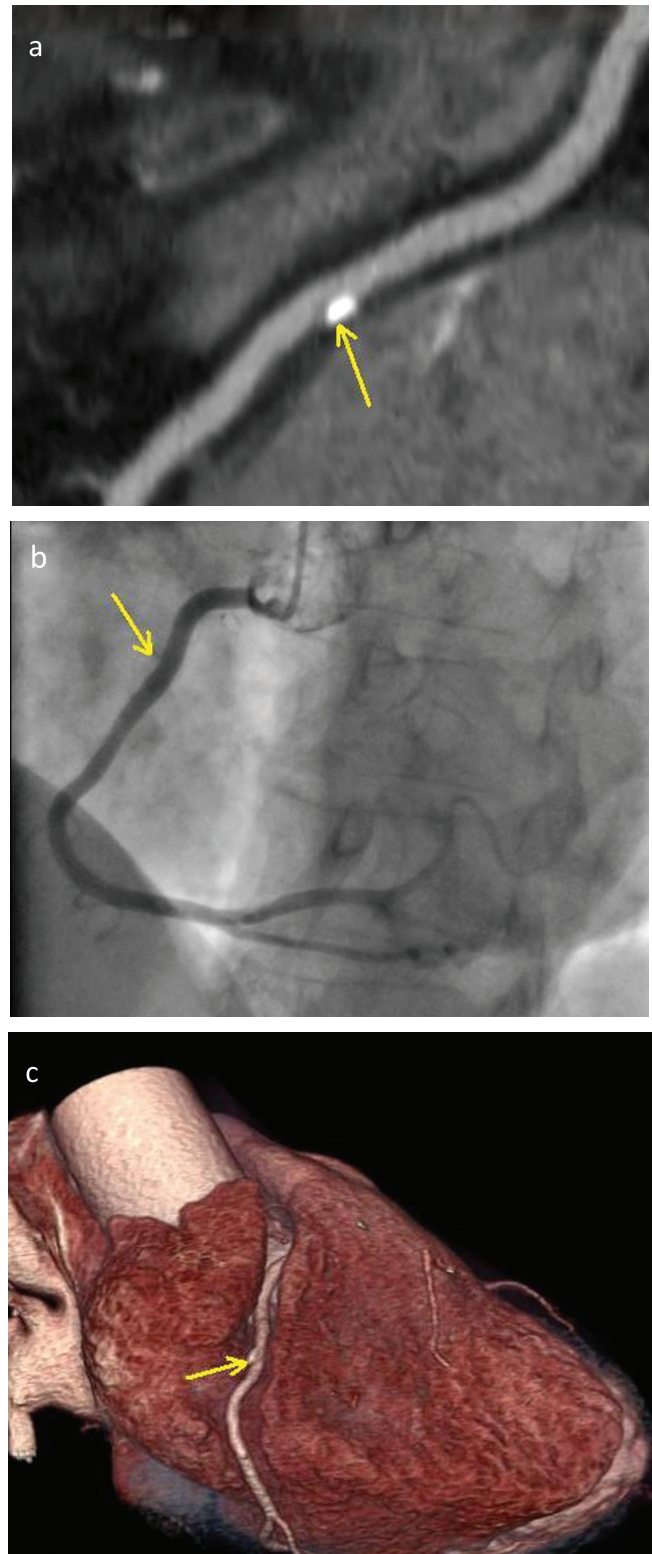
Right coronary artery atheroma. (a) CTCA of curved multiplanar reformation showing a focus of calcified plaque (arrow) with further diffuse, low attenuation non-calcified atheroma along the adjacent vessel wall not causing significant stenosis. (b) Catheter angiography showing a 'normal' vessel lumen. (c) Three-dimensional volume rendering showing the focal calcified plaque in the proximal RCA. CTCA = computed tomographic coronary angiography; RCA = right coronary artery.
